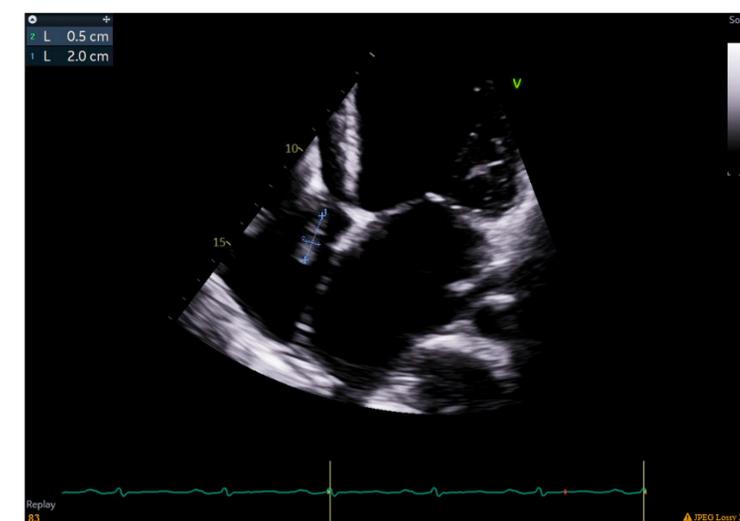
Transthoracic echocardiogram apical 4-chamber view of AICD lead vegetation.
